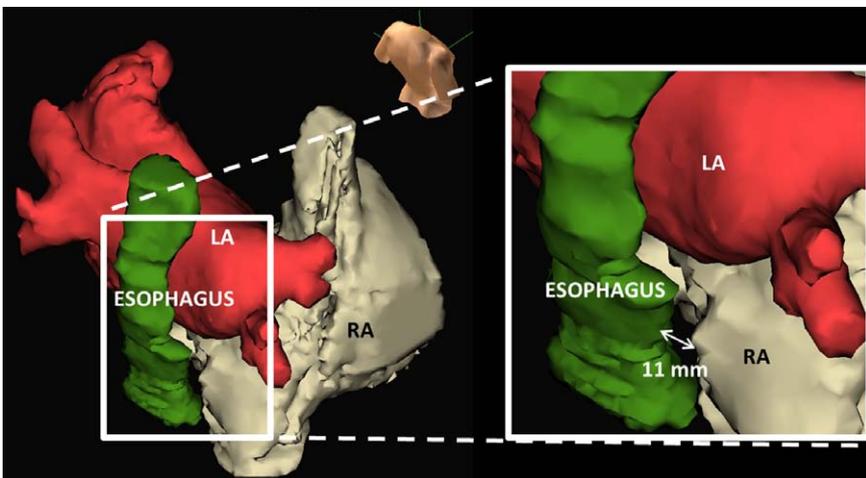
Relationships between right atrium (RA), left atrium, and the esophagus (right lateral view with posterior cranial angulation) of CT reconstruction with distance between the ablation site of the RA and esophagus noted.
